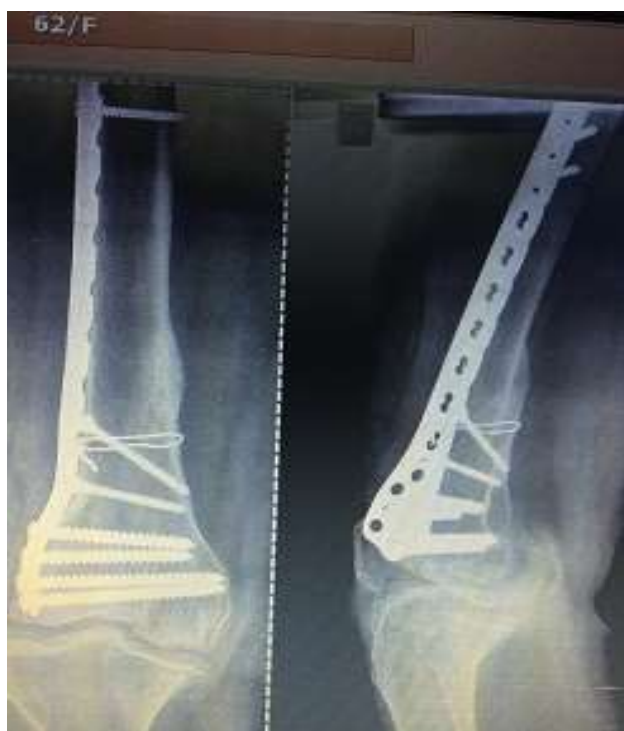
Follow-up X-ray at one year with good healing with implant in situ.
